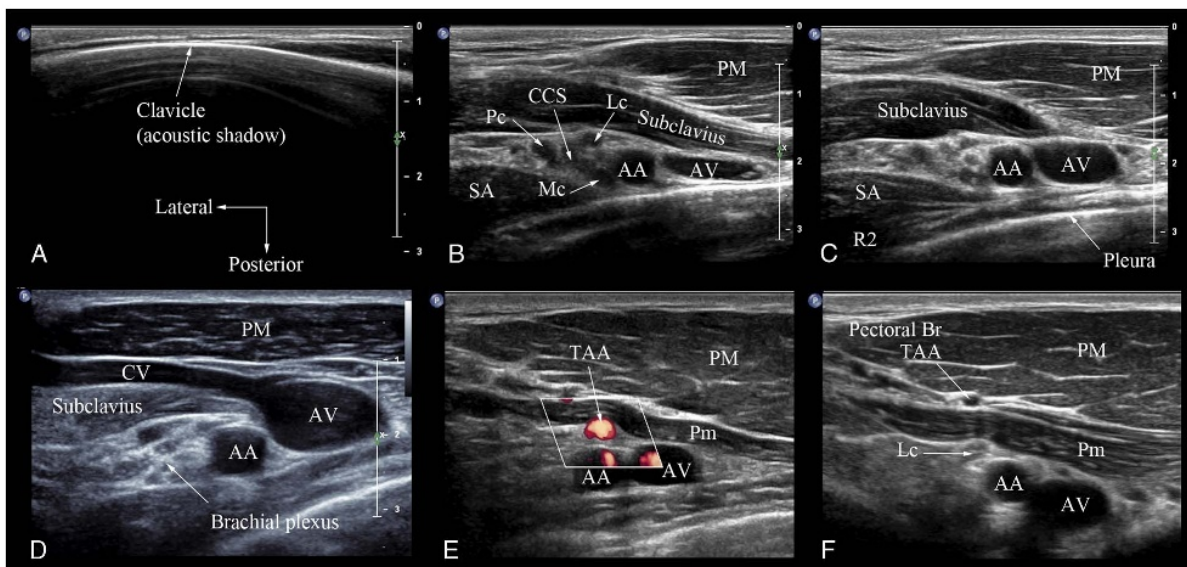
Transverse sonograms show the sonoanatomy relevant for costoclavicular BPB. Note that orientation label has been placed over (A). A, Sonogram obtained with the transducer placed directly over the clavicle. Note the large acoustic shadow of the clavicle (step 1). B, Sonogram shows the CCS immediately caudal to the mid-point of the clavicle (step 2). C, Optimized sonogram of the CCS shows cords lying lateral to the axillary artery (AA) and between the subclavius and serratus anterior (upper slip) muscles. D, Sonogram shows the cephalic vein (CV) arching over the cords of the brachial plexus to join the axillary vein (AV) from a lateral to medial direction (step 3). E, Power Doppler sonogram shows the origin of the thoracoacromial artery (TAA) from the AA close to the upper border of the pectoralis minor muscle (Pm) (step 4). F, Lateral infraclavicular fossa deep to the pectoralis major (PM) and Pm muscles (Step 5). Note the pectoral branch of the TAA in the intermuscular plane between the PM and Pm muscles. LC, lateral cord; Mc, medial cord; Pc, posterior cord; R2, second rib; SA, serratus anterior.
